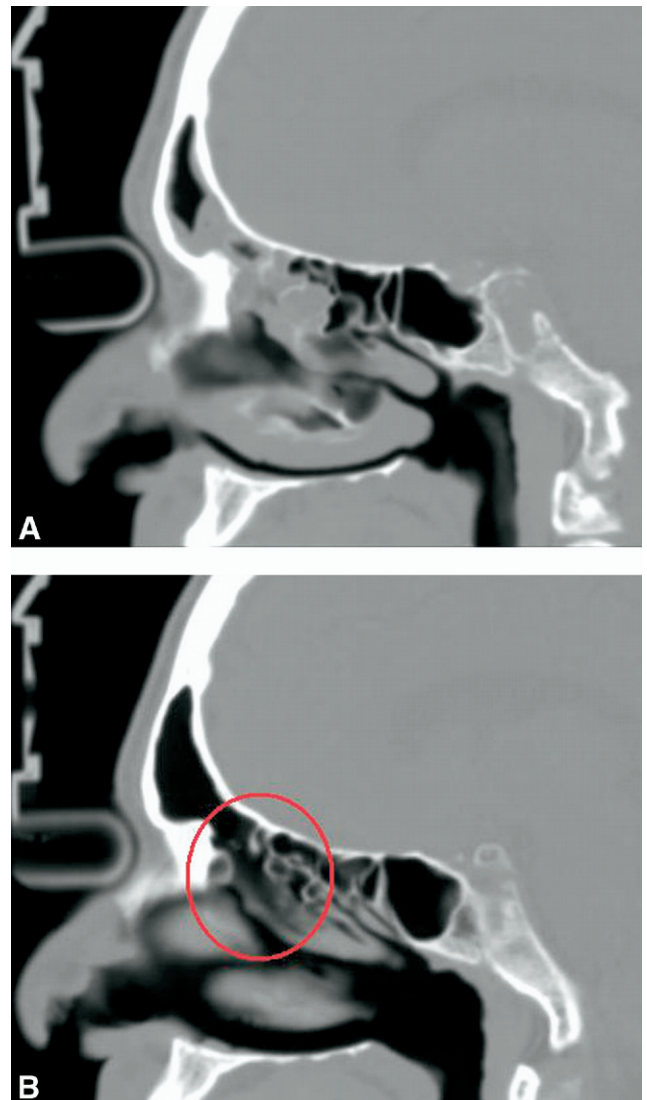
(A) Chronic right frontal and anterior ethmoid disease in a 74-year old treated with three courses of antibiotics. The patient's septum was deviated to the right, decreasing the airway to <4 mm width. The patient was treated with a right balloon frontal sinusotomy and irrigation; no septoplasty, ethmoidectomy, or maxillary antrostomy were performed; and no antibiotics were given. (B) One-year postoperative CT sagittal reconstruction of the patient in 4A. Right frontal sinus is clear. Right ethmoid sinus has cleared with no other treatment.
